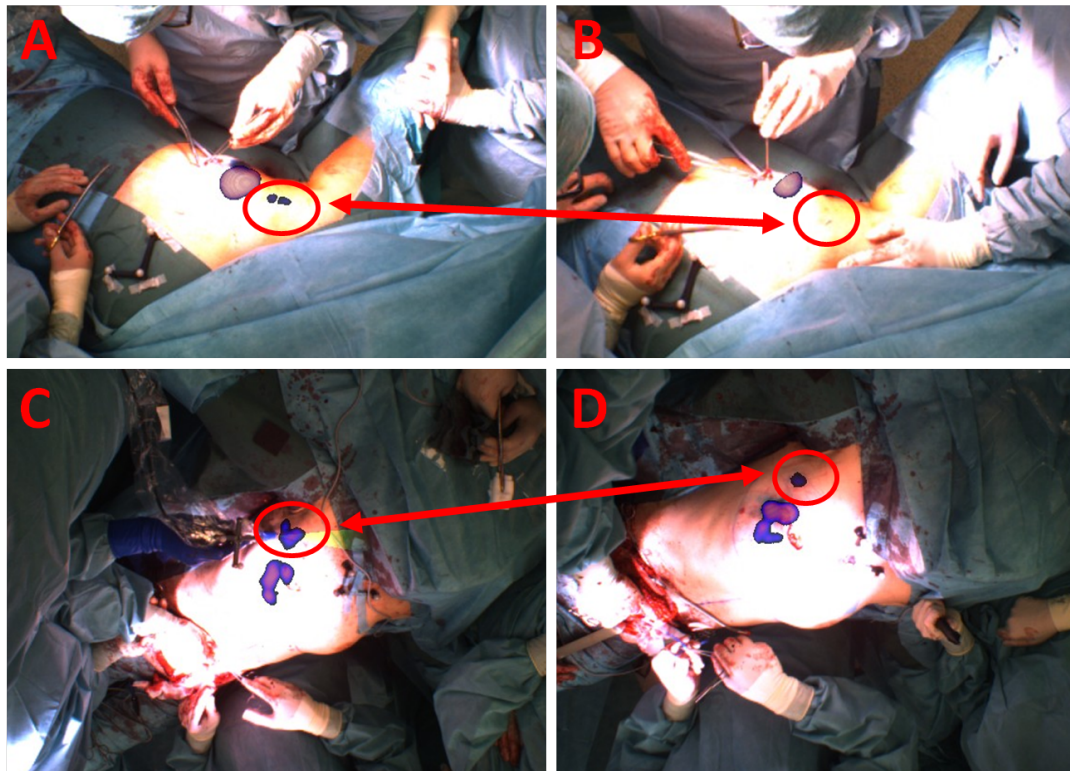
(A) Pre-incision freehand SPECT overlaid on post-excision situs to be able to compare with current situation as seen in (B). Here the two SLNs were removed cleanly. On the other hand in (C) and (D) part of the radioactivity is still inside the axilla. Freehand SPECT allows an impartial comparison before and after resection.
